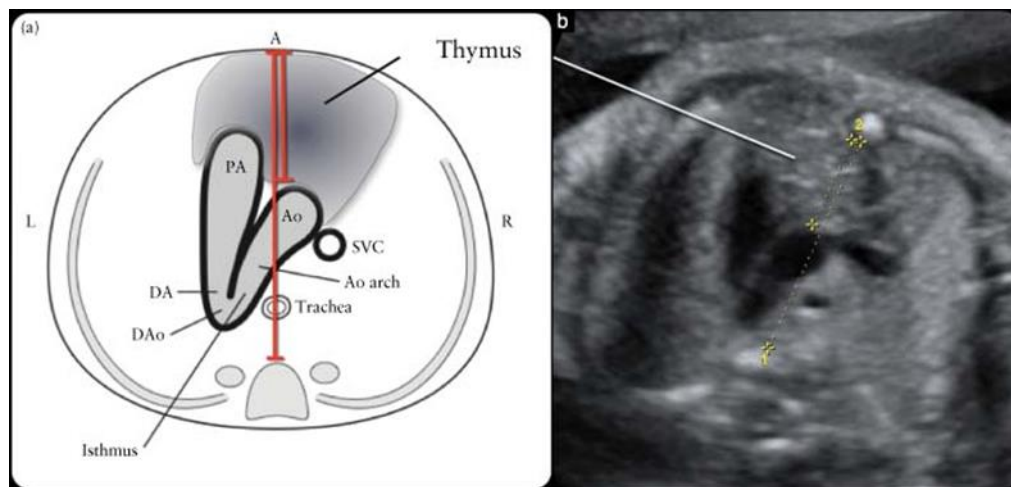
Three-vessel-trachea view shown on gray scale ultrasound
